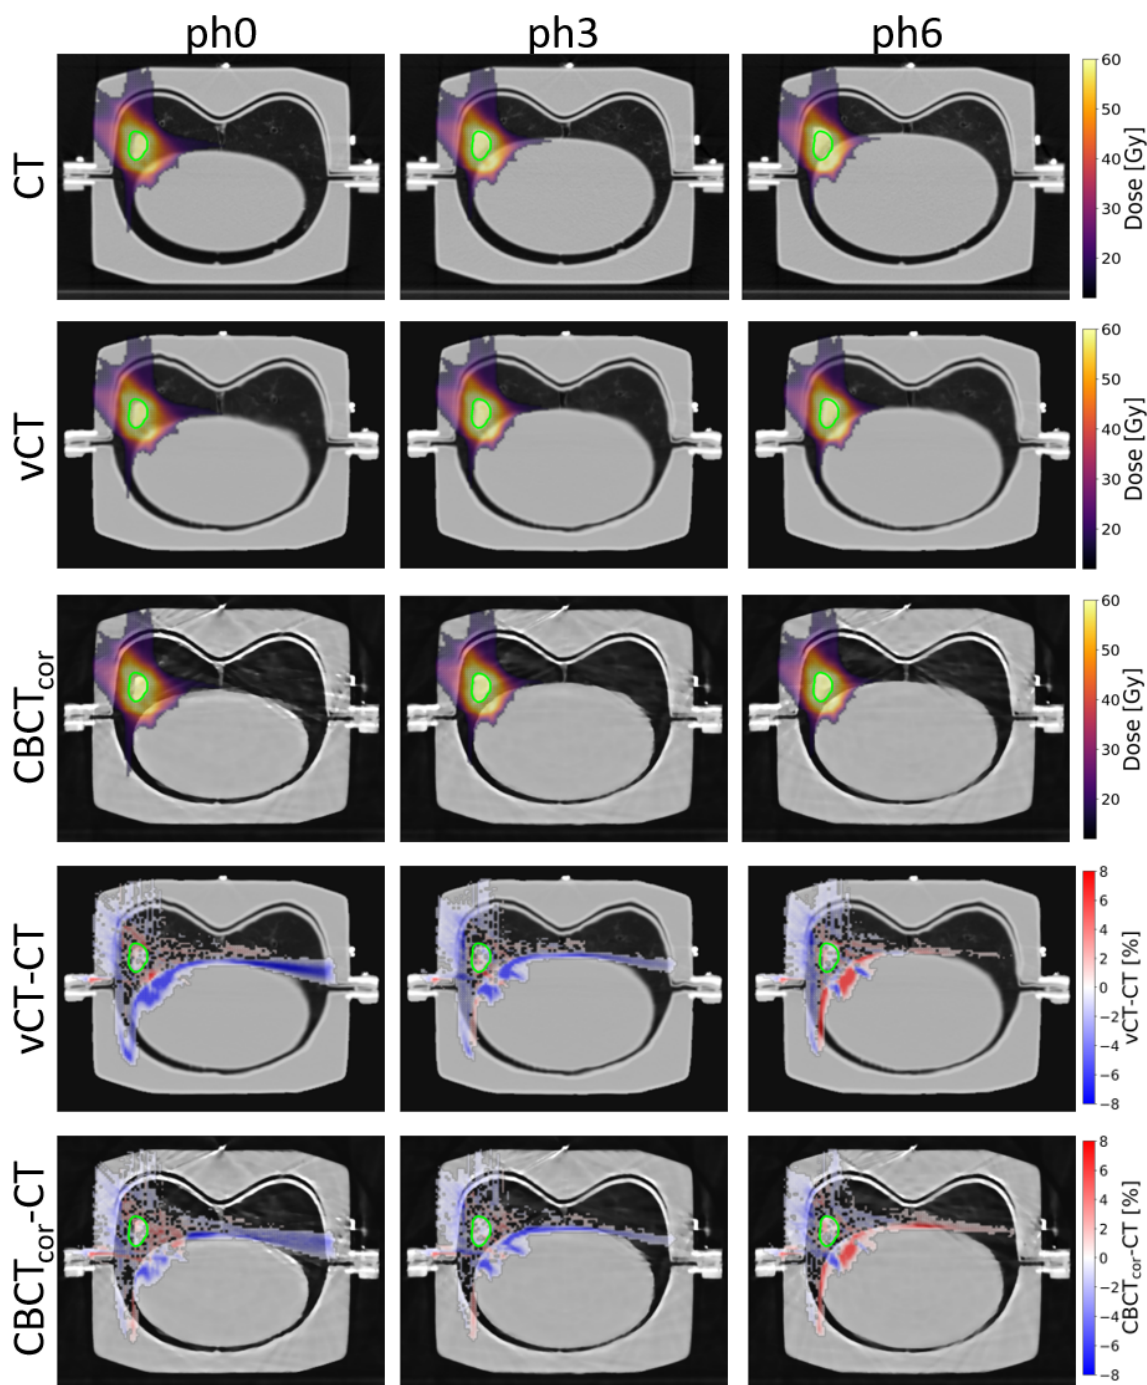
The first three rows show proton dose calculations for ITV_4 for three different phases of 4DCT, 4DvCT, and 4DCBCT_{cor}. Dose values below 15 Gy are masked to improve clarity. The two bottom rows display dose differences, which are expressed as percentages of the prescribed dose. To improve clarity in the dose difference images dose differences smaller than 0.4% are not shown. The images are displayed with level = -300 and window = 1600. Figure reprinted from [168].
